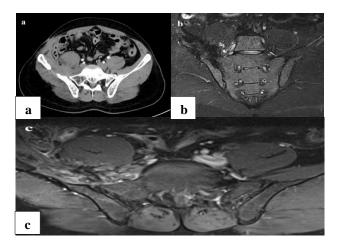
Shows (a) post-operative CECT scan (after 6 months) shows bulky right psoas muscle and no residual hematoma; b) coronal TRIM sequence shows hyperintense signal changes along the right lumbar plexus, no residual hematoma is seen; and (c) axial T1 weighted post contrast MRI shows smooth enhancement along the lumbar plexus. No residual hematoma is seen.
